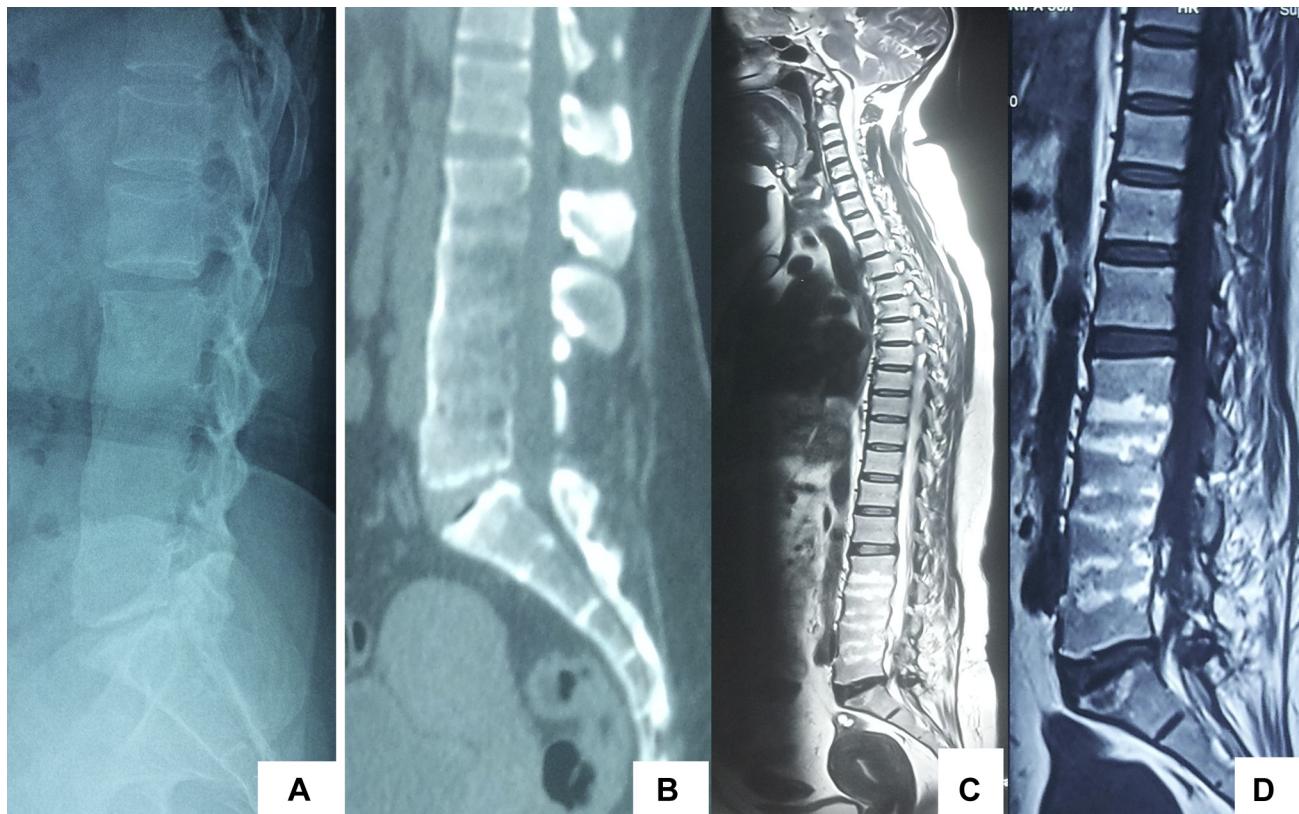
Late postoperative images of spine (A) X-ray of lumbosacral spine—lateral view (B) computed tomography of lumbosacral spine—sagittal view (C) sagittal T2W of whole spine (D) sagittal TIW of lumbosacral spine.
